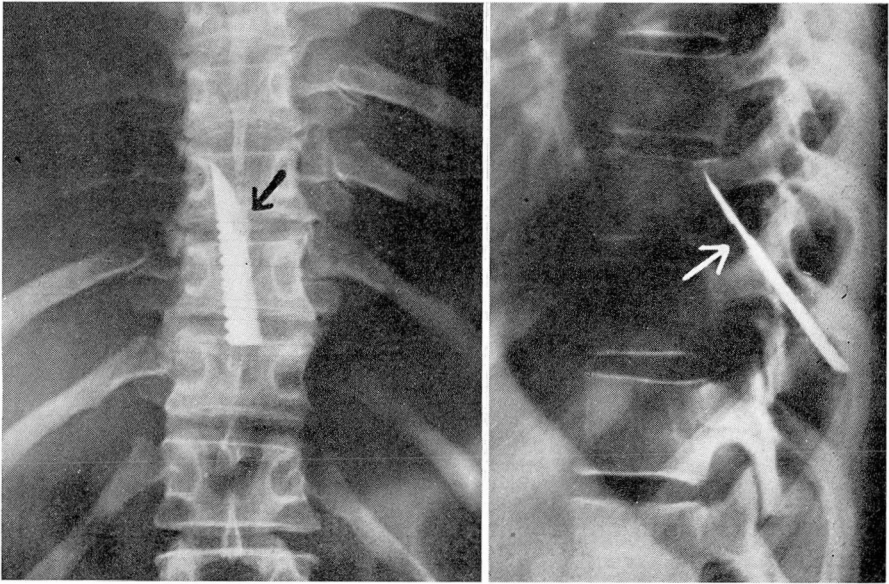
Roentgenograms showing position of blade. Arrows point to location of nick within spinal canal.
